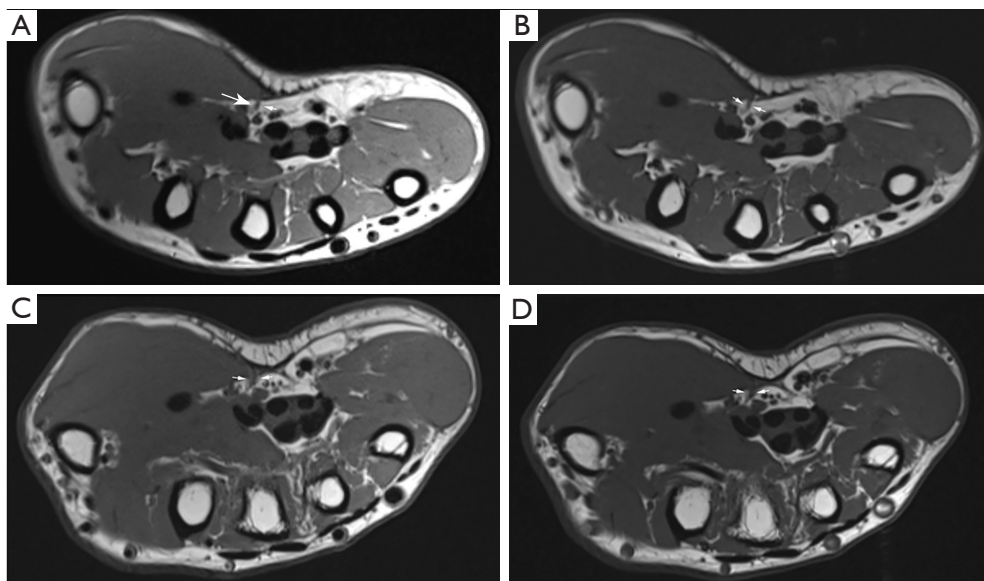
Magnetic resonance imaging of the RMB. (A,C) Cross-sectional proton density-weighted images. (B,D) Cross-sectional T1-weighted images. (A,B) A case in which the RMB visibility was rated as excellent. (C,D) A case in which the RMB visibility was rated as moderate. The arrows indicate the long axis of the RMB. RMB, recurrent motor branch.
